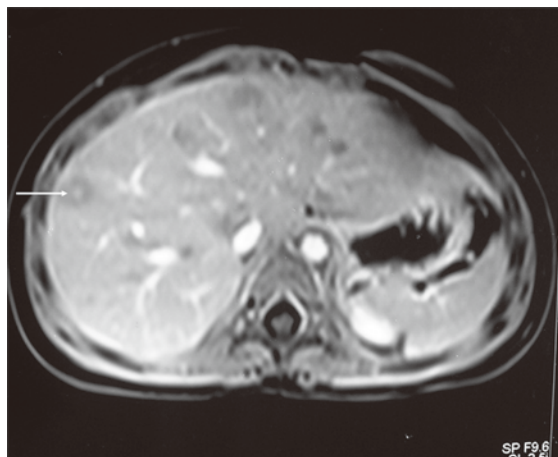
MRI of the abdomen (post contrast) showing multiple nodules in both lobes of the liver with faint central enhancement (arrow).
